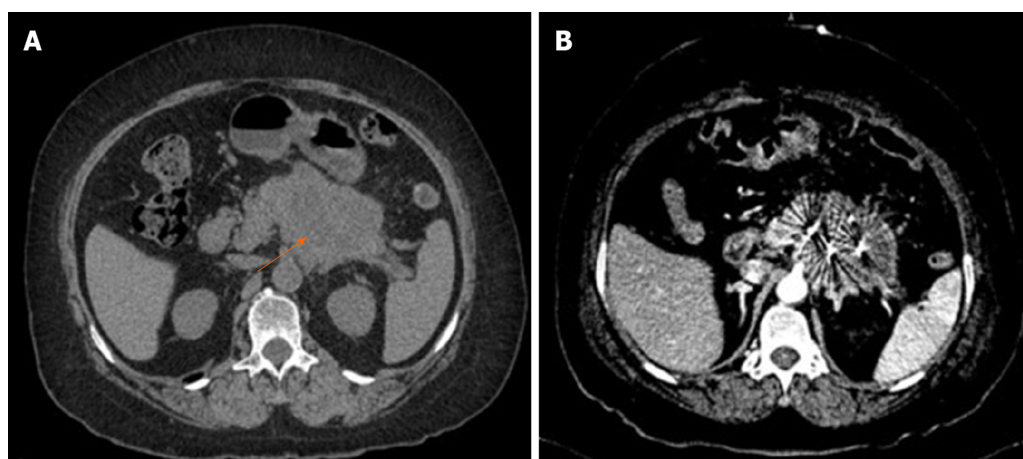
Radioactive ^{125}I seed implanted in locally advanced pancreatic cancer. A: Preoperative computed tomography (CT) showed locally advanced pancreatic cancer (arrow); B: Postoperative CT showed the radioactive ^{125}I seeds implanted in the tumor.
